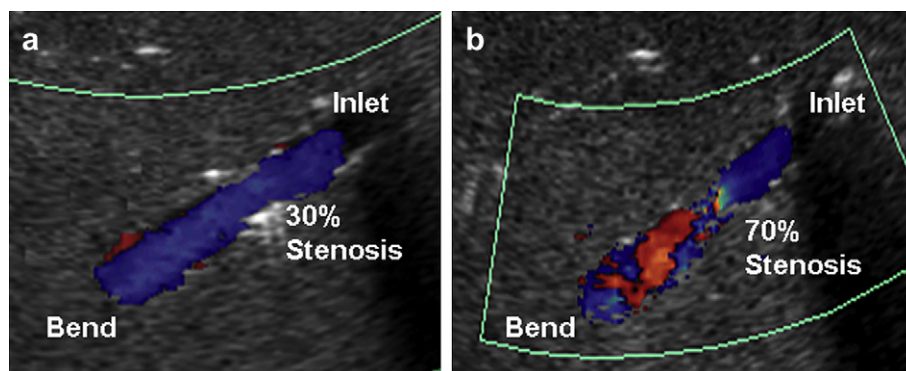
Colour Doppler images showing (a) the inlet region of the vessel with 30% stenosis, a small area of reverse flow is present at the bend and (b) the inlet region of the vessel with 70% stenosis, turbulent and reverse flow are evident post stenosis.
